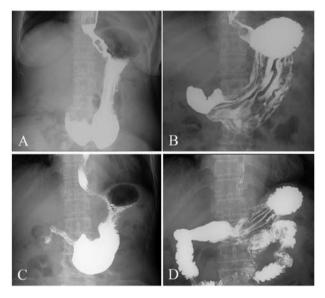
Different types of gastric morphological type for T1 stage and T2 stage GC. (A) Filling image and (B) mucosal image for the case of a 58-year-old female with GC located at the upper segment; Upper gastro-intestinal barium X-ray examination diagnosed a weak-type stomach. The postoperative pathology data proved to be of a moderately differentiated adenocarcinoma, intestinal-type GC and T2 stage disease. (C) Filling image and (D) mucosal image for the case of a 73-year-old male with GC located at the lower segment; Upper gastrointestinal barium X-ray examination diagnosed a hook-type stomach. The postoperative pathology data proved to be of a moderately differentiated adenocarcinoma, mixed-type GC and T1 stage disease. GC, gastric cancer.
